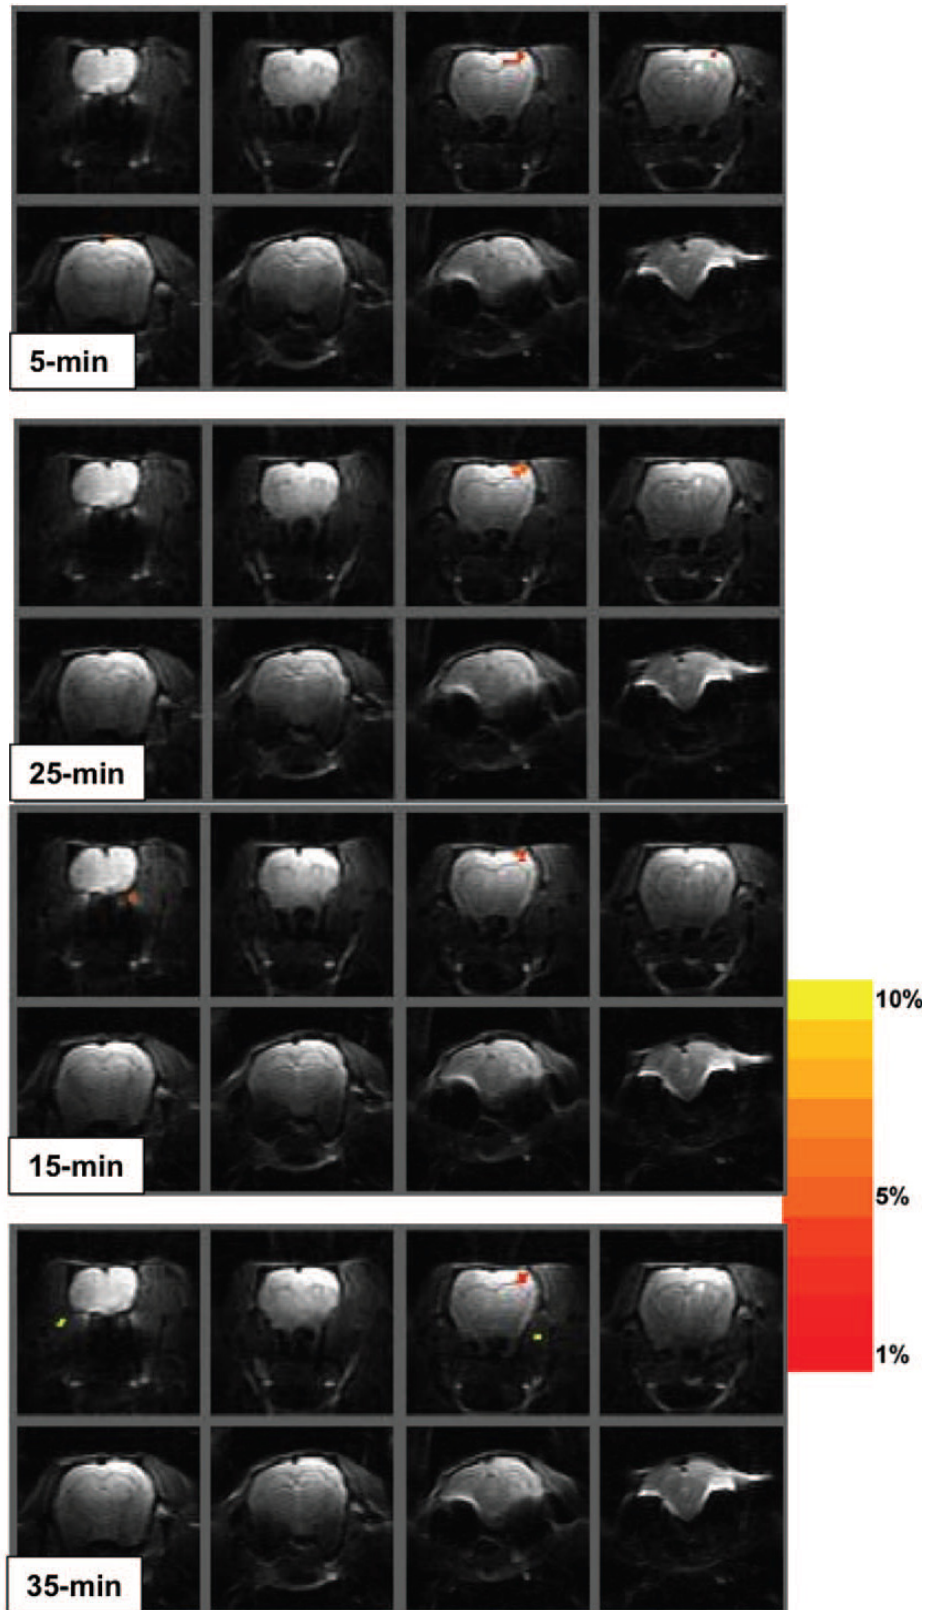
Blood-oxygen-level-dependent (BOLD) activation maps of the responses to 2mA forepaw stimulation for 30s obtained during control conditions (no lidocaine) derived from EPI magnetic resonance imaging
